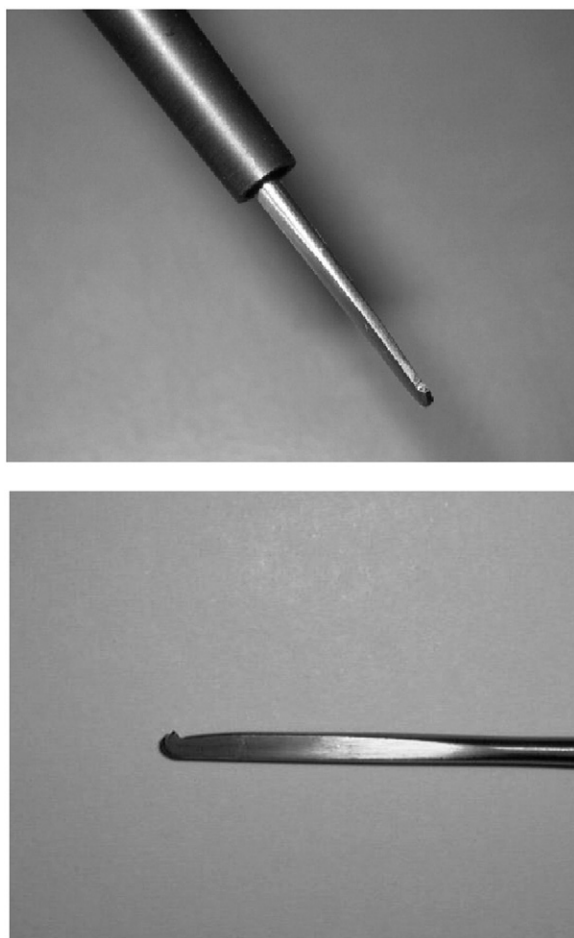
Photographs of a scalpel-type ultrasonic bone curette, of which the tip is 0.7 mm wide: superior oblique view of the tip (upper) and lateral view of the tip (lower).
